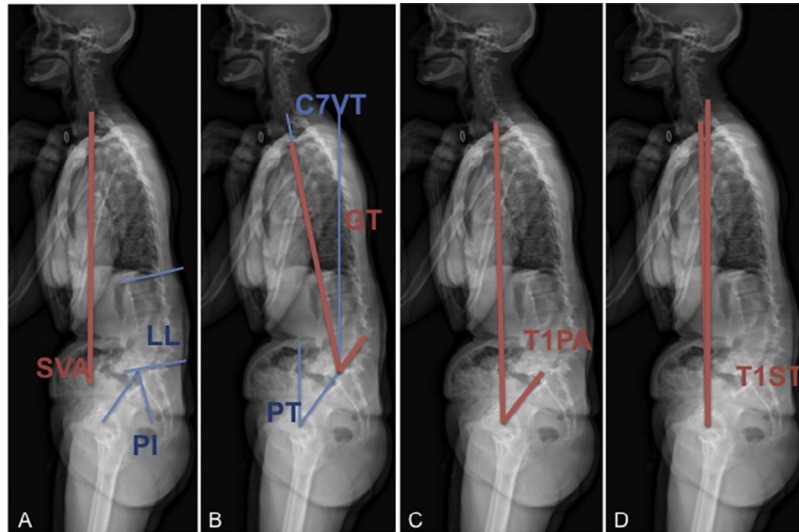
Radiographic measured parameters (mean normal values in asymptomatic population): (A) sagittal vertical axis ($-6.9 \text{ mm} \pm 34.8$), lumbar lordosis ($57.2^\circ \pm 13$), pelvic incidence (49.6 ± 12.1), lumbar lordosis index (ratio between lumbar lordosis and pelvic incidence [LL/PI]) ($57.2/49.6=1.2$); (B) global tilt (23.2° after 50 years old); (C) T1 pelvic angle ($8.6^\circ \pm 8.5$; 17.9 after 50 years old); (D) T1 sagittal angle ($-1.35^\circ \pm 2.7$).
